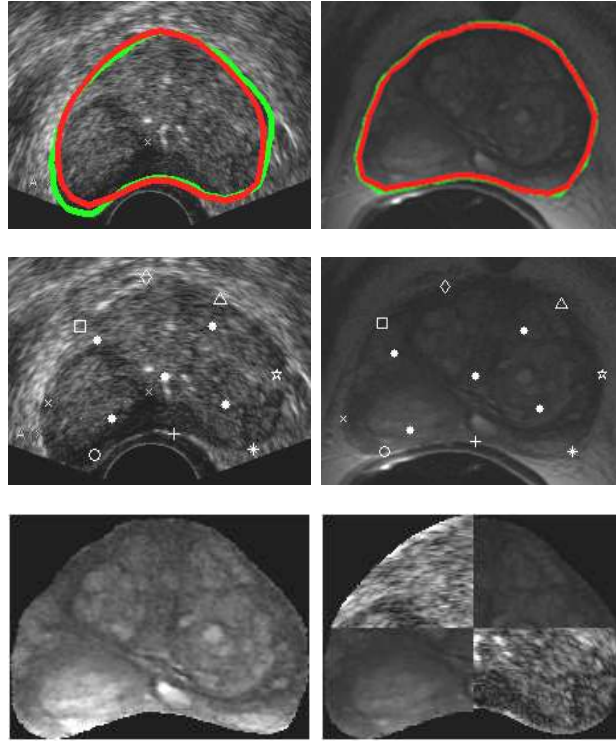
Qualitative registration results with point correspondences established according to automatically segmented prostate contours. The first row shows the contours obtained using automatic segmentation method (in red) and manual segmentation (in green) on both TRUS and MR images. The second row shows the point correspondences on the prostate for both the TRUS and MR images and the third row shows the resulting fused TRUS-MR image and the TRUS-MR checker-board.
